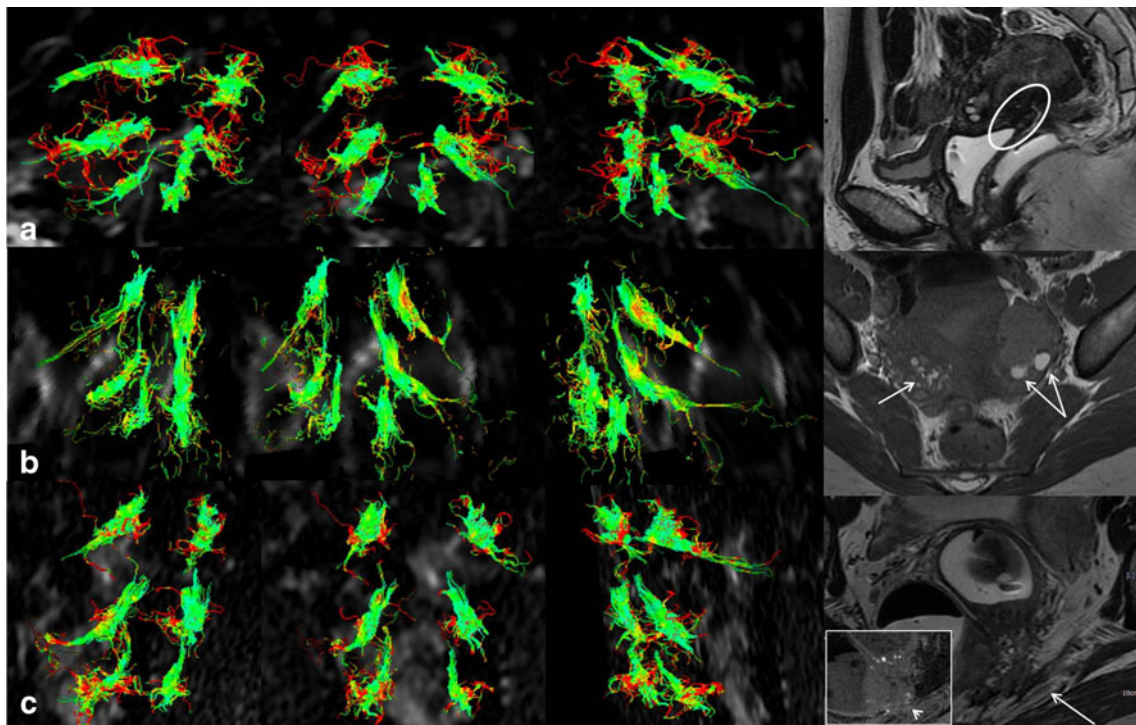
Fibre tracking reconstruction in three women affected by endometriosis of the posterior compartment (A), of the medium (B) and of both (C). The fibre bundles in all three cases are short, stubby and have lots of branches. In A, T2-weighted fast recovery fast spin echo (FSE) image (sagittal plane) shows an endometriosis implant located in the posterior vaginal fornix (*circle*), which is elevated and associated with a
